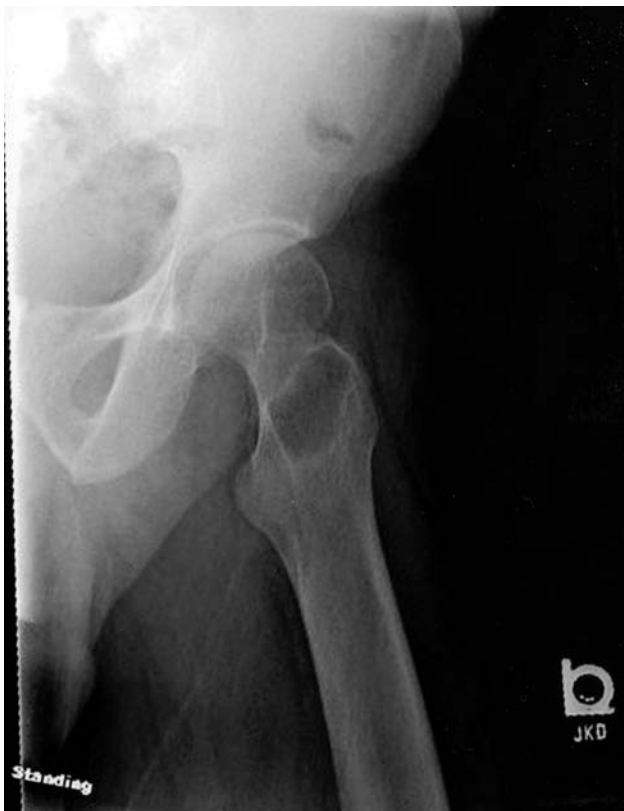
Radiograph of the left hip shows the large lesion within the neck of the femur to be sharply marginated with a mildly sclerotic border and a narrow zone of transition.
